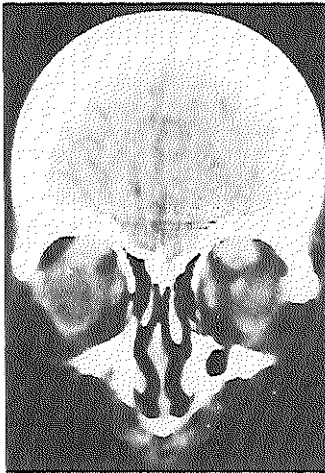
Coronal CT-scan of patient B with primary hypothyroidism and severe OGD, showing massive bilateral enlargement of the superior complexes.
